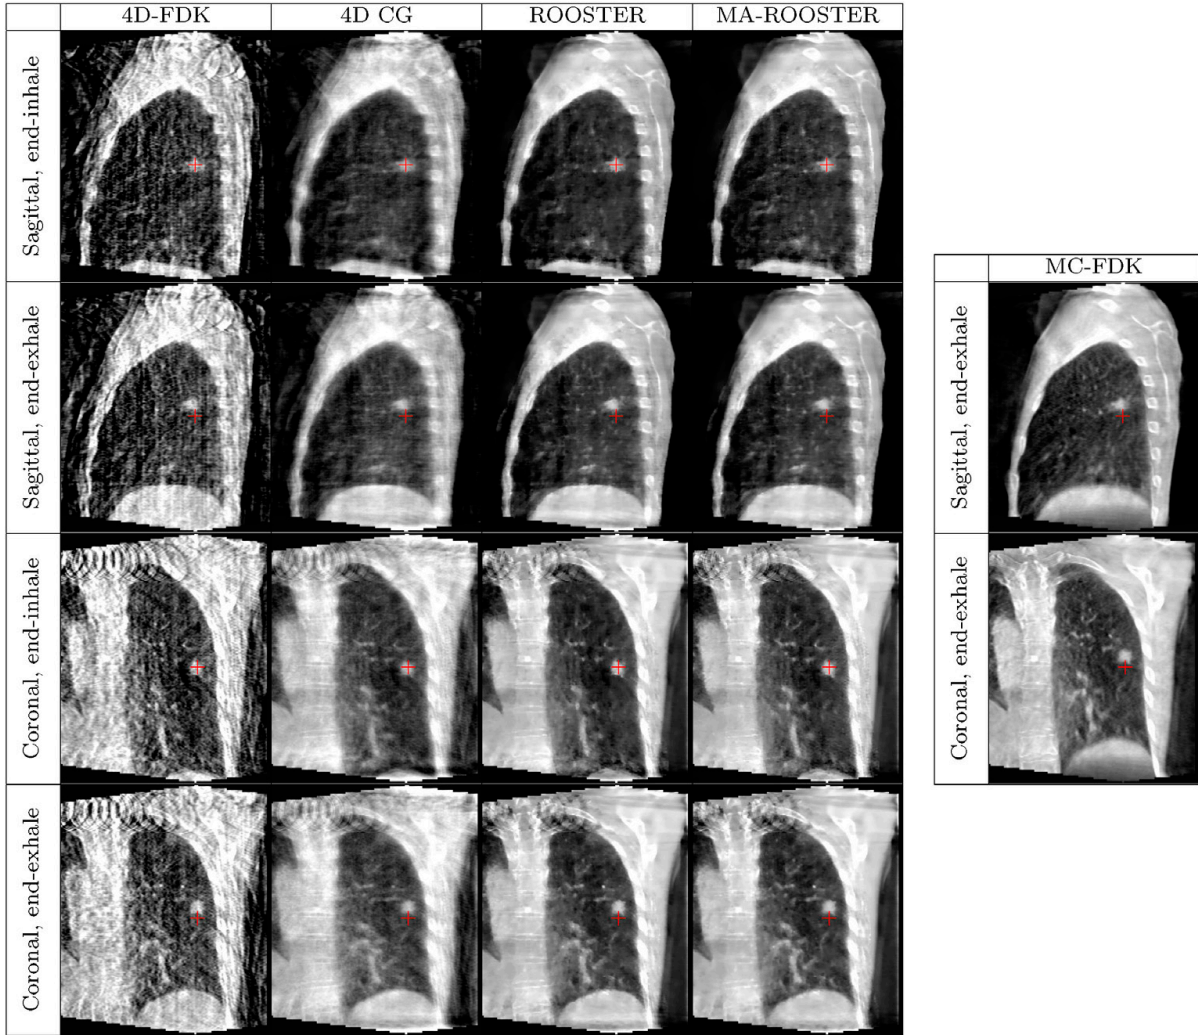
Sagittal and coronal slices of 4D cone-beam CT images reconstructed with several methods (FDK, CG, ROOSTER and MA-ROOSTER) and 3D MCFDK. Figure re-printed from [J37].
